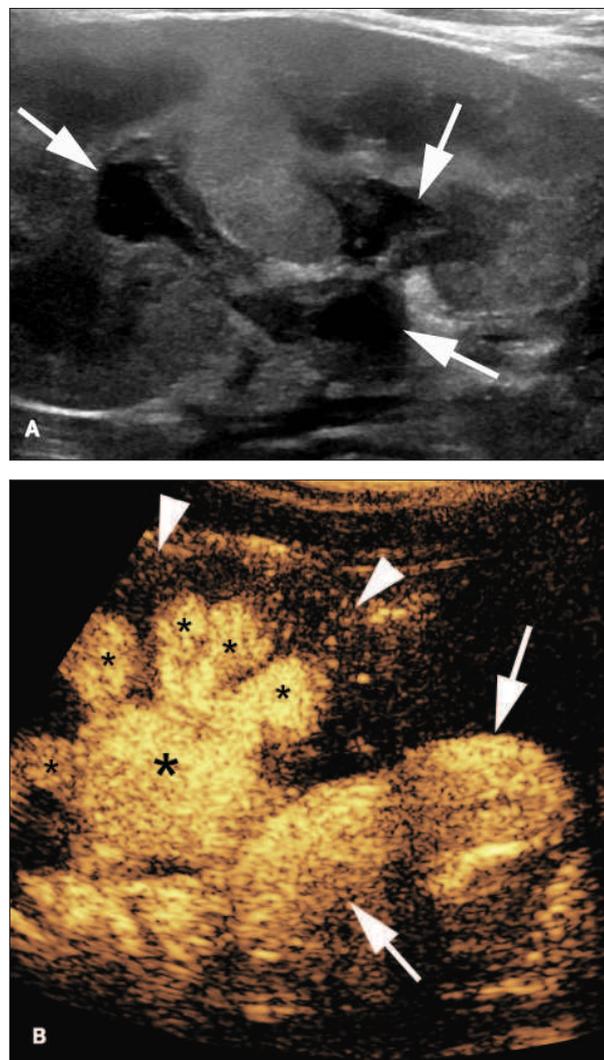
(continued) C, Sagittal sonogram of the left kidney during contrast-enhanced voiding urosonography reveals diffuse parenchymal enhancement at the peak of reflux due to the presence of IRR. D, Anteroposterior supine image of the abdomen and pelvis during VCUG shows grade IV to V left-sided VUR with a dilated ureter, pelvis, and calyces. There is striking left IRR (arrowheads). E, Posterior pinhole image of the left kidney on Tc-99m-DMSA scintigraphy reveals multiple cortical defects (arrowheads). F, Posterior pinhole image of the right kidney on Tc-99m-DMSA scintigraphy shows a prominent upper pole defect (arrowhead).
